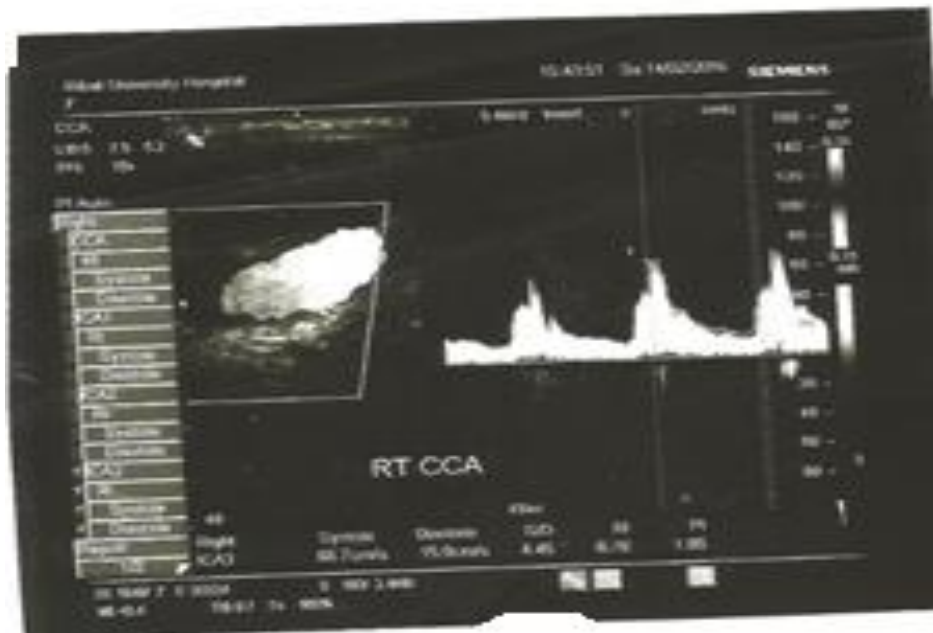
Rt ICA-female- 50 years diabetic patient with normal Doppler parameters.
